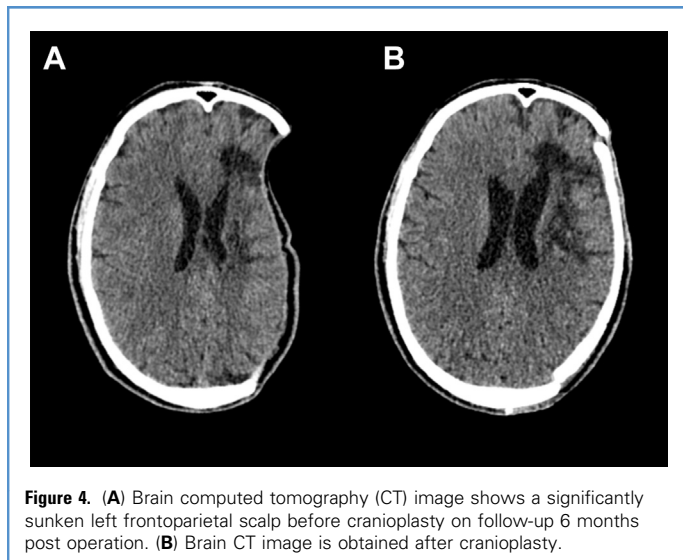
(A) Brain computed tomography (CT) image shows a significantly sunken left frontoparietal scalp before cranioplasty on follow-up 6 months post operation. (B) Brain CT image is obtained after cranioplasty.
